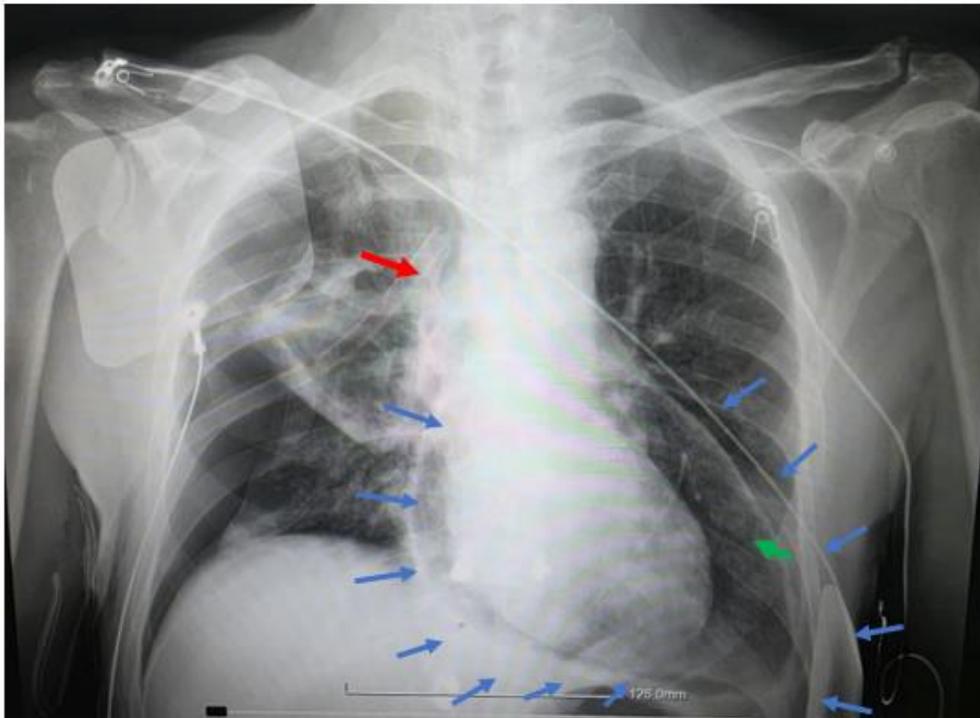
Chest X-ray showing pneumopericardium with concurrent right pneumothorax. Blue arrows define the borders of pericardium. A right pleural drainage tube (red arrow) and a pericardial drainage tube (green arrow) are visible.
